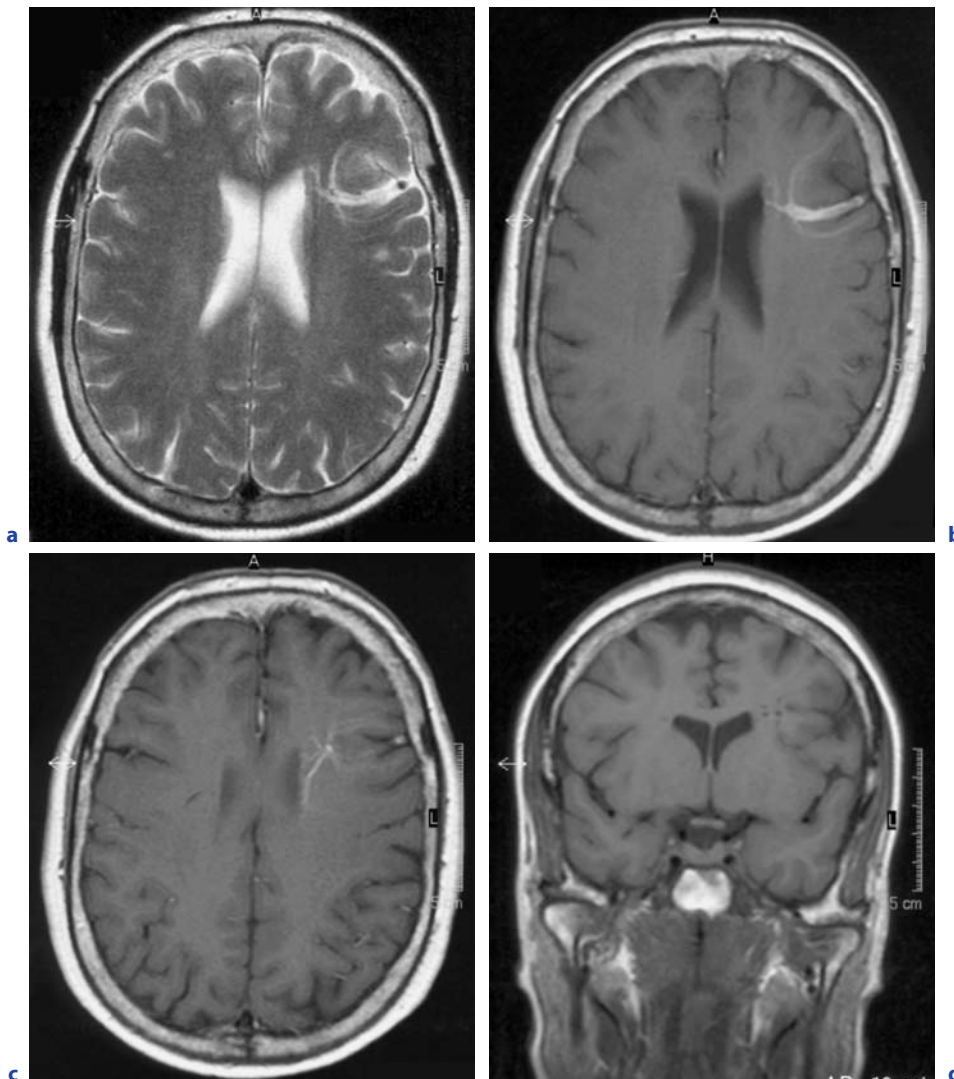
Axial T2-weighted (a) and contrast-enhanced T1-weighted (b) magnetic resonance imaging reveal a large transcerebral draining vein. Note the enlarged perivascular space around the vein on T2 image (a) and the coronal T1 image without contrast enhancement (d). The Medusa head is visible with starlike configured small draining venoles (c)
